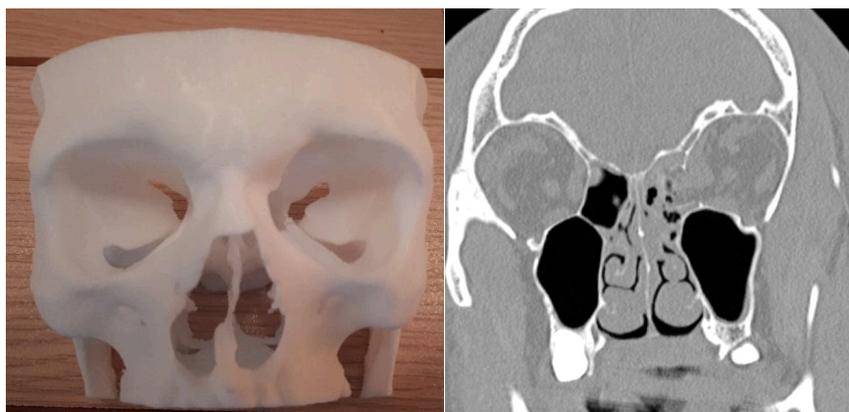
CT scan and 3D model of interior wall fracture
